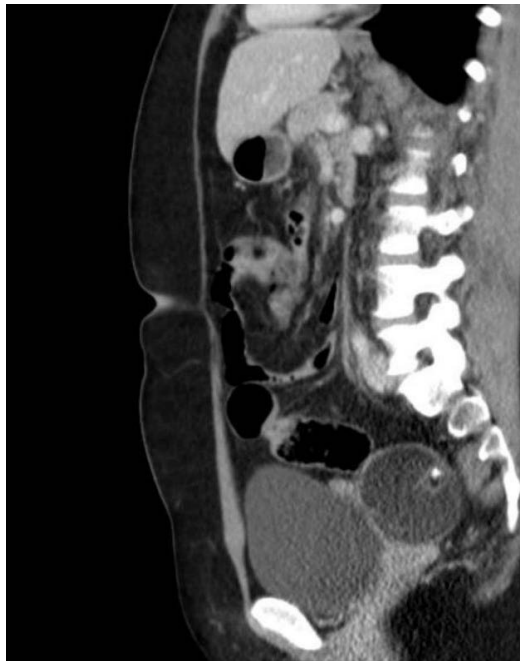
Abdomino-pelvic CT scan showing no metastatic location. Source: Radiology Department, CHU Andrainjato Fianarantsoa, Madagascar.
